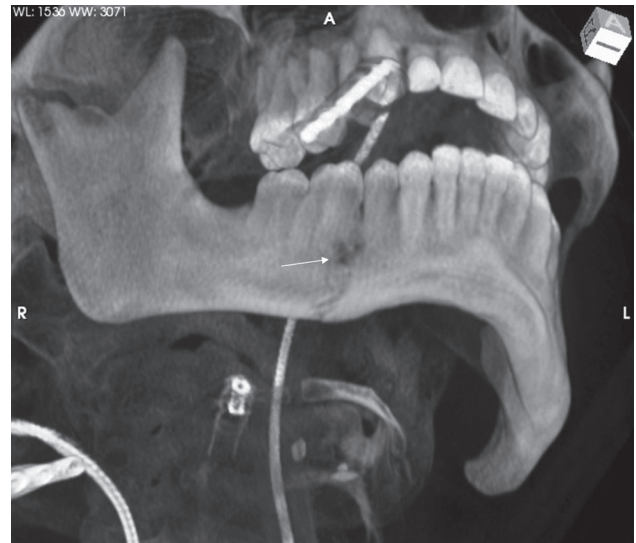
Preoperative three-dimension computed tomography showing three mental foramina at the right side of the mandible
